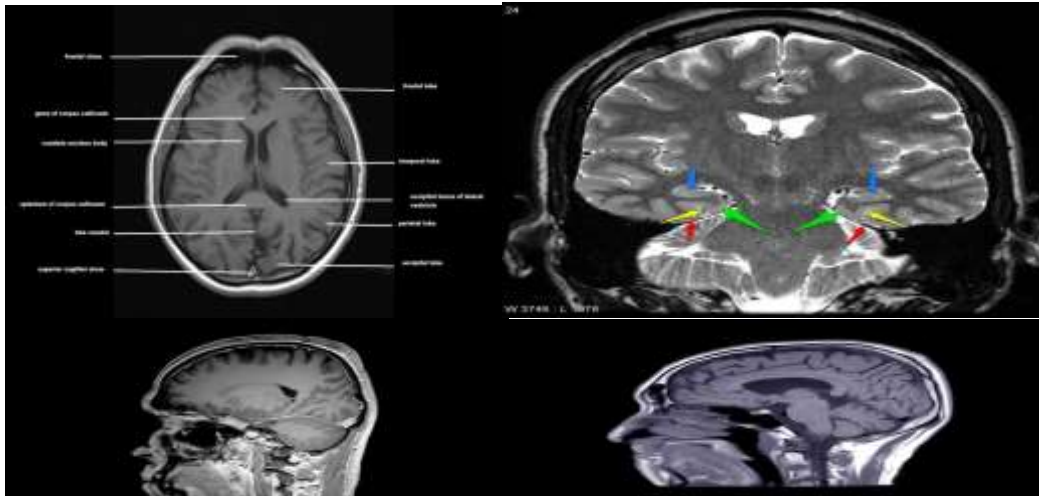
Structural MRI – Normal Control (NC)
